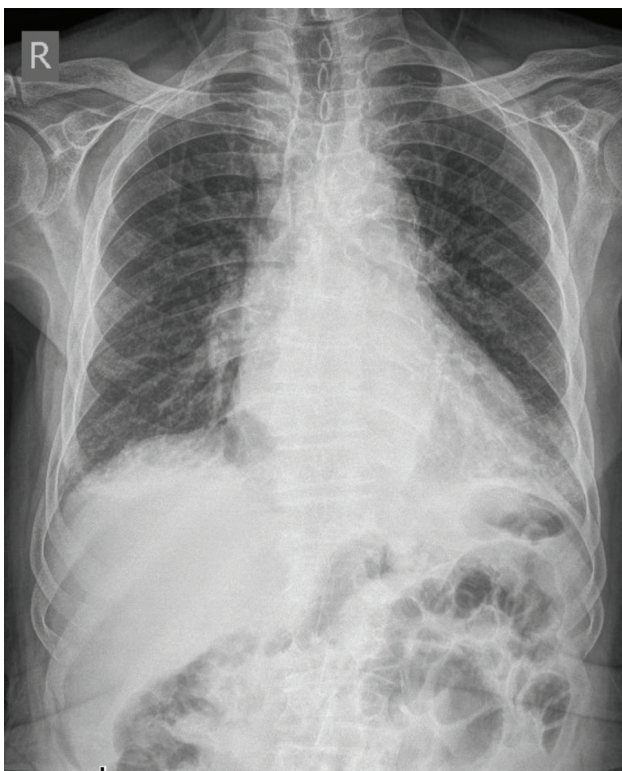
Chest X-ray on hospital admission.
